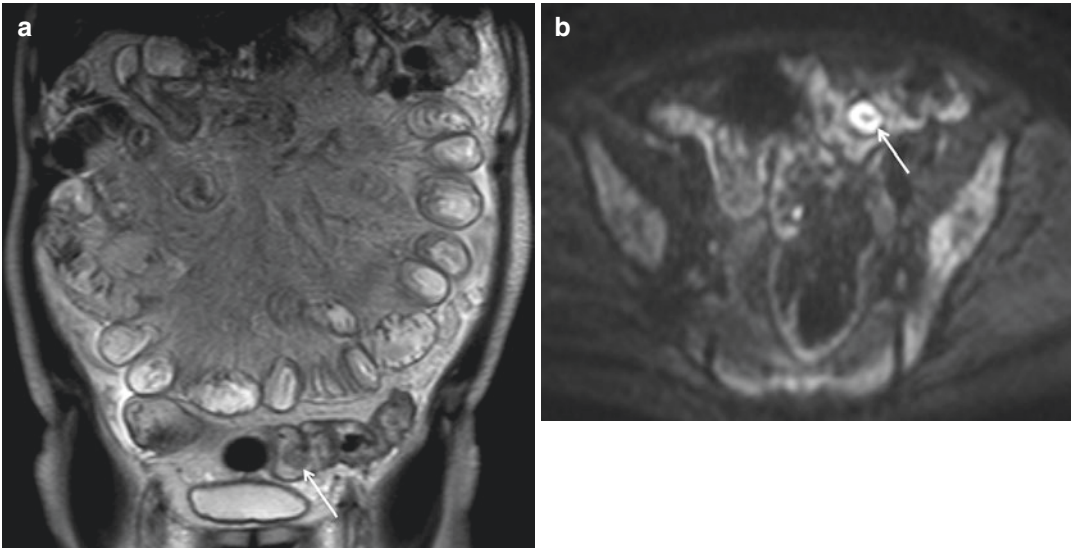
Coronal T2-w HASTE scan (a) shows a slightly hypointense round lesion within the sigmoid lumen (arrow) characterized by high-intensity signal on DWI at
